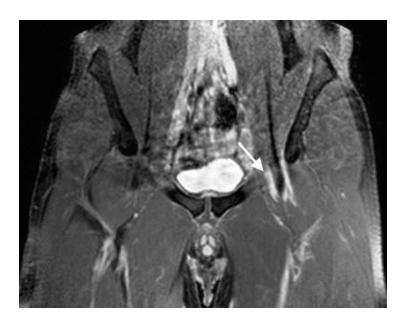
Coronal contrast-enhanced T1-weighted SPIR pelvic MRI shows hypersignal at the myotendinous junction of the left iliopsoas (arrow)
